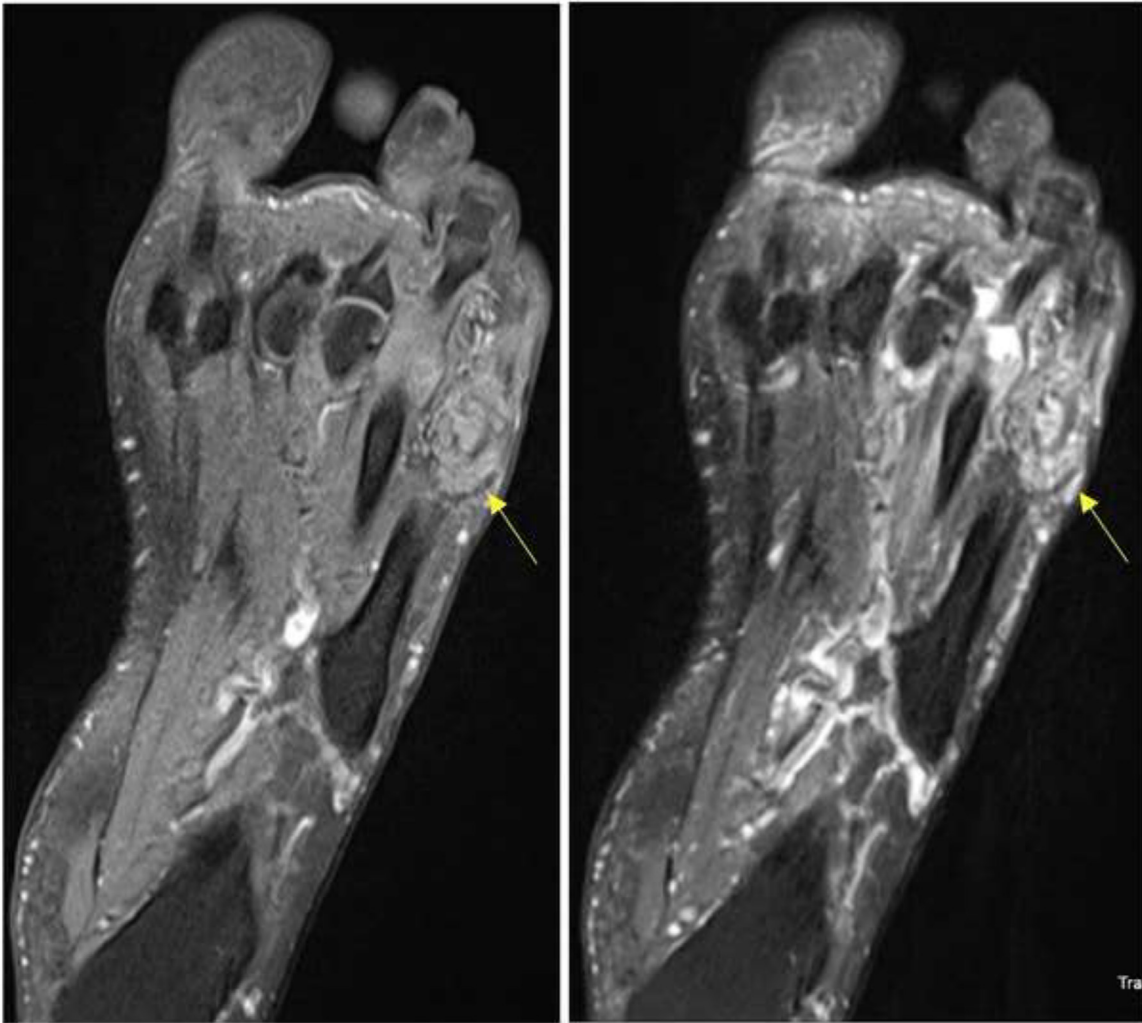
Case 1. Coronal MRI sections in fat-suppressed T1 (A) and fat-suppressed proton data weighting (B), showing iso- to hyperintense lesions corresponding to mycetoma grains, 1 of them having a central hypointense dot, making the characteristic “dot in a circle sign”. Note also effusion of the 3rd, 4th and 5th metatarsophalangeal joints as well as synovial thickening.
